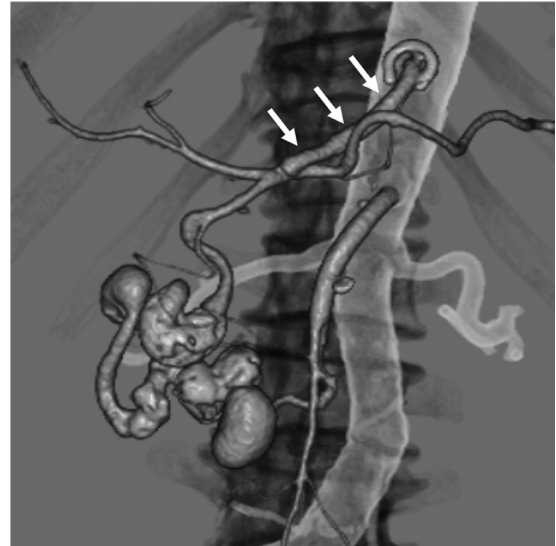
3D-CTA revealed the bypass from the supra-coeliac aorta to the common hepatic artery (arrows).
